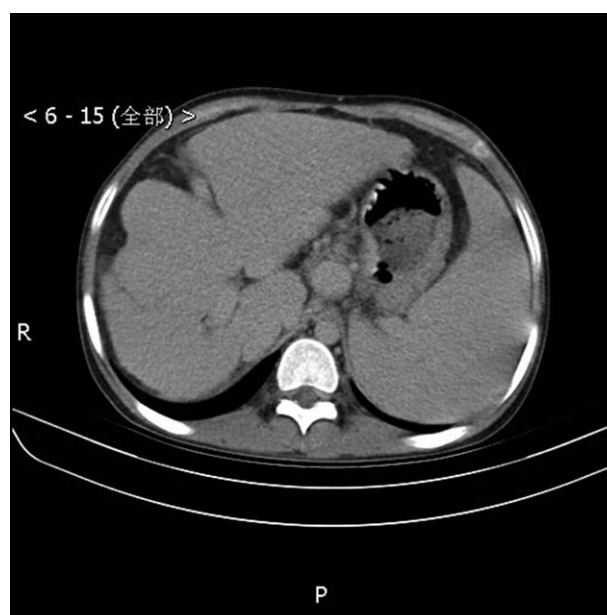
Computed tomography of the upper abdomen and chest revealed cirrhosis, portal hypertension, collateral circulation formation, large spleen, and ascites on August 22, 2016.
